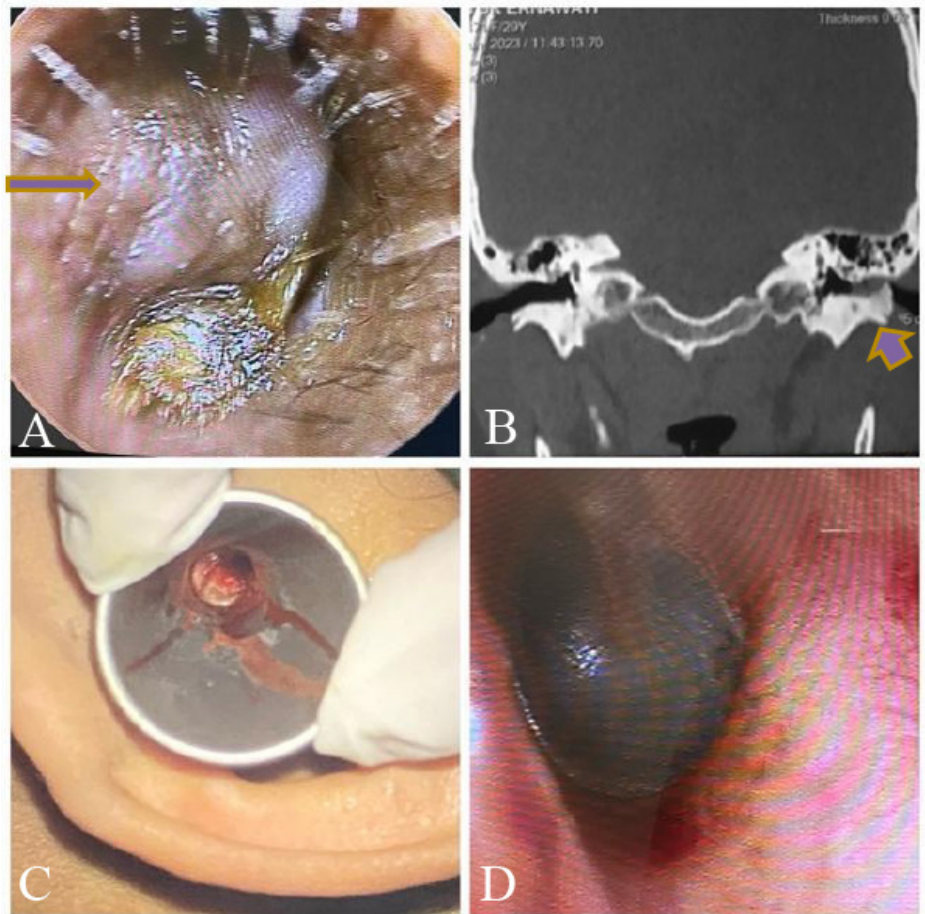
Image of a 29-year-old woman with external auditory exostosis. (A) Endoscopic image showing the left external auditory canal, the lesion almost covers 90% of the external auditory canal. (B) Temporal bone CT scan shows a dense mass on the left auditory canal. (C) image of the lesion during the surgical procedure. (D) Follow-up of endoscopic view 4 weeks after surgery. The patient was asymptomatic and free of complications or relapse.
